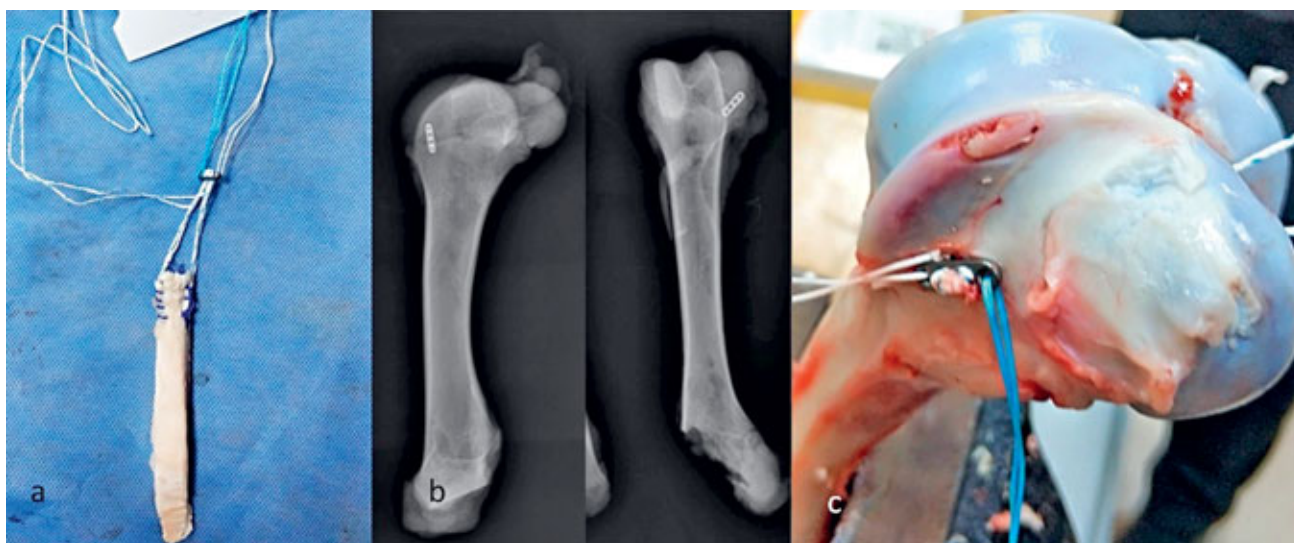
a – QTT graft prepared with the ASS device; b – AP and lateral X-rays showing the placement of the ASS and tunnel position; c – titanium button passed from the tunnel and seated on the lateral cortex before loading the tendon into the tunnel.
